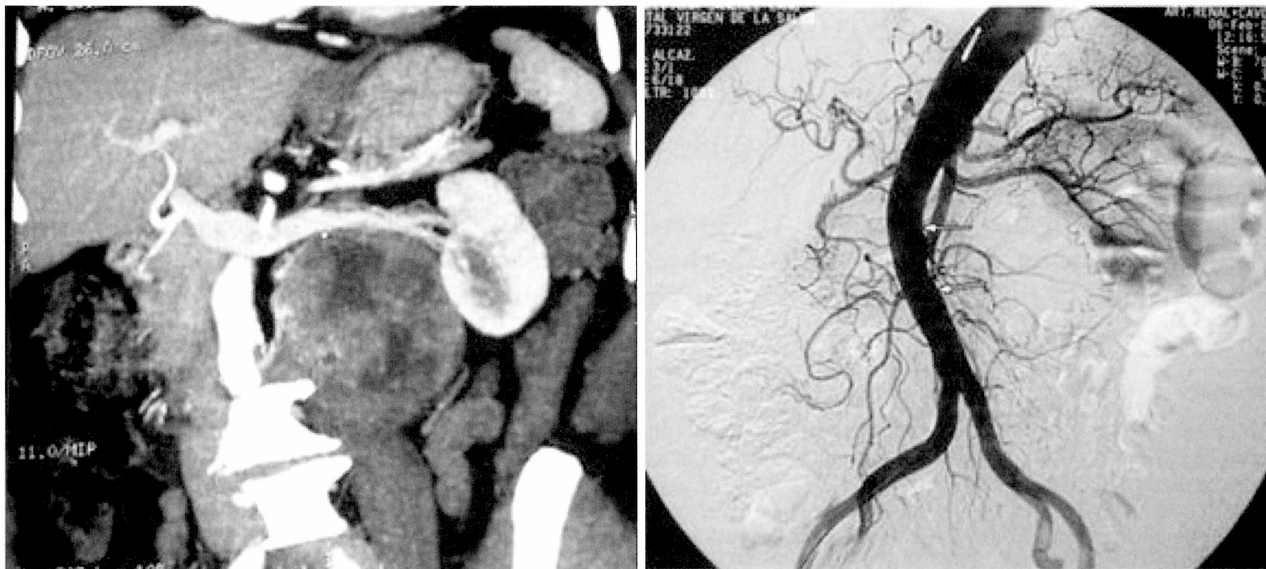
CT scan and arteriography image.
